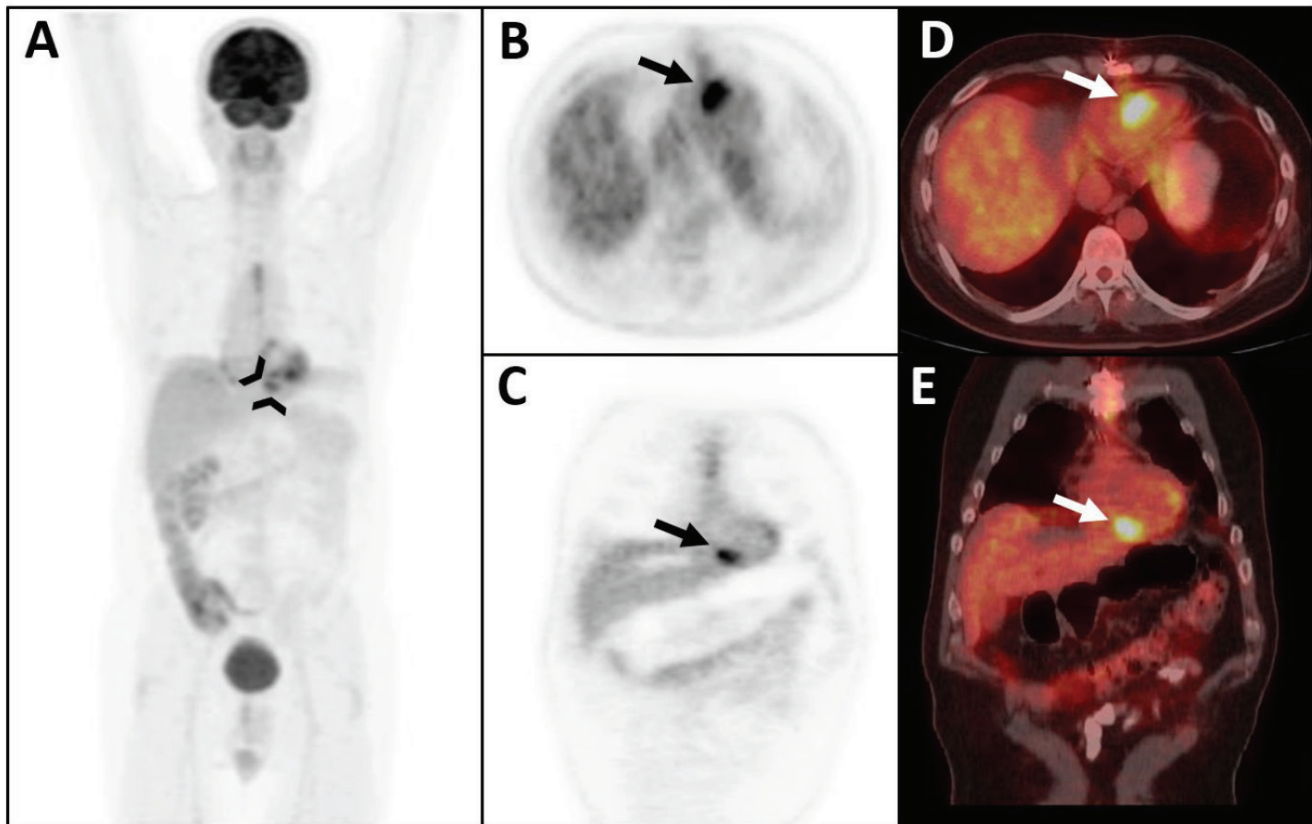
A 45-year-old man with a history of orchiectomy 21 years ago due to yolk sac tumor underwent thoracoabdominal computed tomography (CT) for routine follow-up. A left adrenal mass and a cardiac soft tissue lesion in the right ventricle were detected. After that, the adrenal mass and cardiac lesion were excised surgically. Pathology report of the adrenal mass was consistent with mature teratoma, but the cardiac lesion was diagnosed as primitive neuroectodermal tumor (PNET). One month after surgery, ¹⁸F-fluorodeoxyglucose (¹⁸F-FDG) positron emission tomography (PET)/CT was performed to evaluate disease status. Maximum intensity projection (MIP) image (A, black arrowheads), axial and coronal PET (B, C, black arrows), and PET/CT fusion (D, E, white arrows) images of PET/CT scan revealed increased FDG uptake in the right ventricle area, previous surgery site, without any marked pathology on CT component of the study, which was interpreted as probable residual malignant disease, indicating that surgery with R0 margin safety cannot be guaranteed in such surgical excision of cardiac tumoral masses. Moreover, it is not usual to observe physiologic FDG uptake in the right ventricle in particular where no physiologic FDG uptake is not seen in the left ventricle or elsewhere in the heart, unless there is an underlying clinical situation of other etiologies such as right ventricular hypertrophy and cardiac failure, which are not present in this patient. There was no other abnormal FDG uptake in the rest of the body in favor of metastasis.
